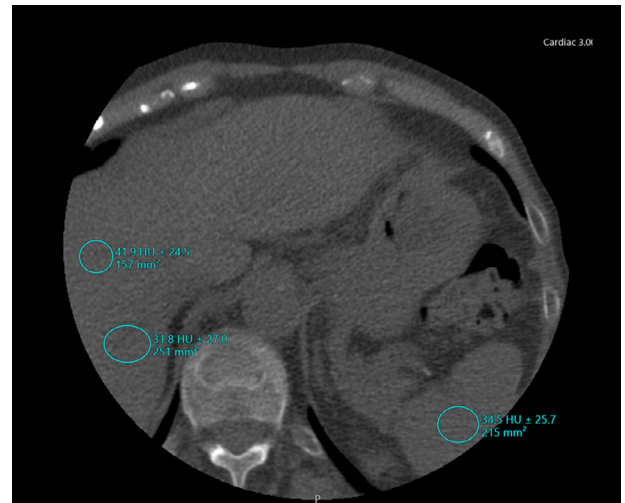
Noncontrast CT to evaluate nonalcoholic fatty liver disease. The regions of interest  $>100 \text{ mm}^2$  in area included 2 regions that were aligned with the anterior-posterior dimension of the right liver lobe and 1 region that was aligned with the spleen. In the liver, the regions of interest avoided inclusion of any large vessels or biliary structures. A liver-to-spleen attenuation ratio  $<1.0$  was considered the cut-off value for a positive diagnosis of nonalcoholic fatty liver disease.
